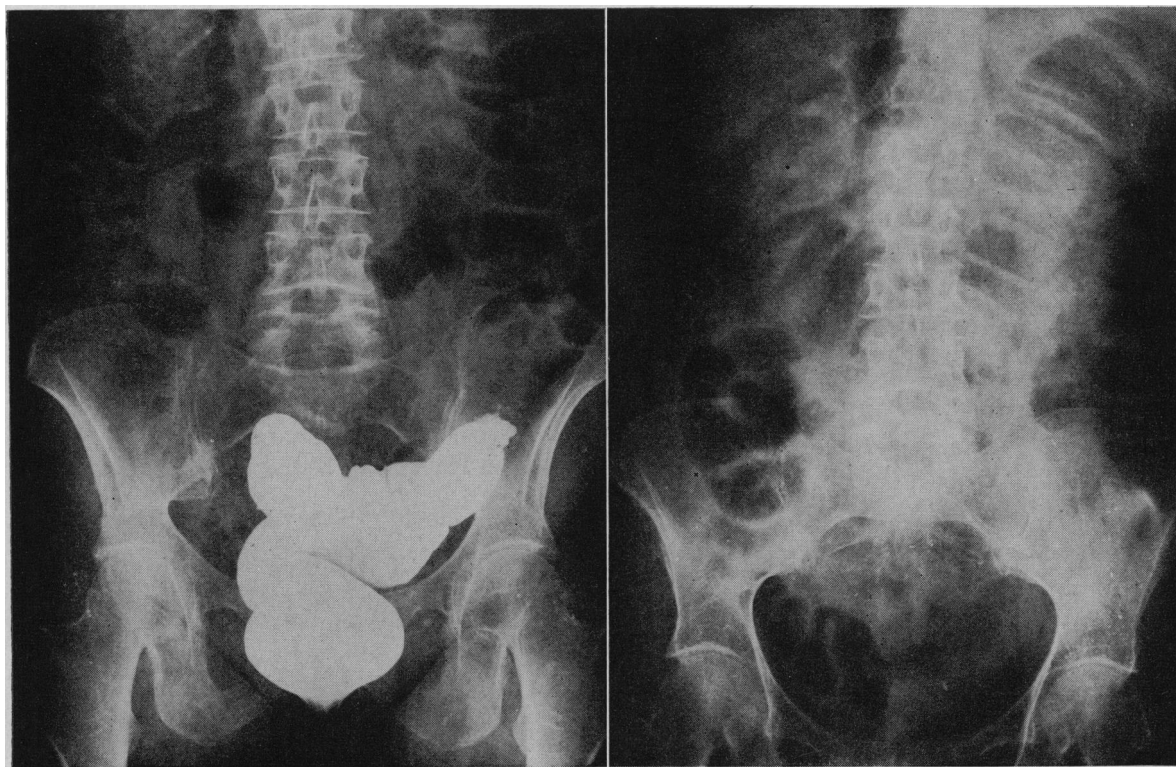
Left:* Plain film of the abdomen in a patient, aged 58, with evidence of complete intestinal obstruction for three days but with a history of having vomited only once. Distention was pronounced. Note the distended loop with haustral markings typical for large bowel. *Right:* Same patient. Barium enema revealed an obstruction in the sigmoid colon. A diagnosis of carcinoma was obvious.
